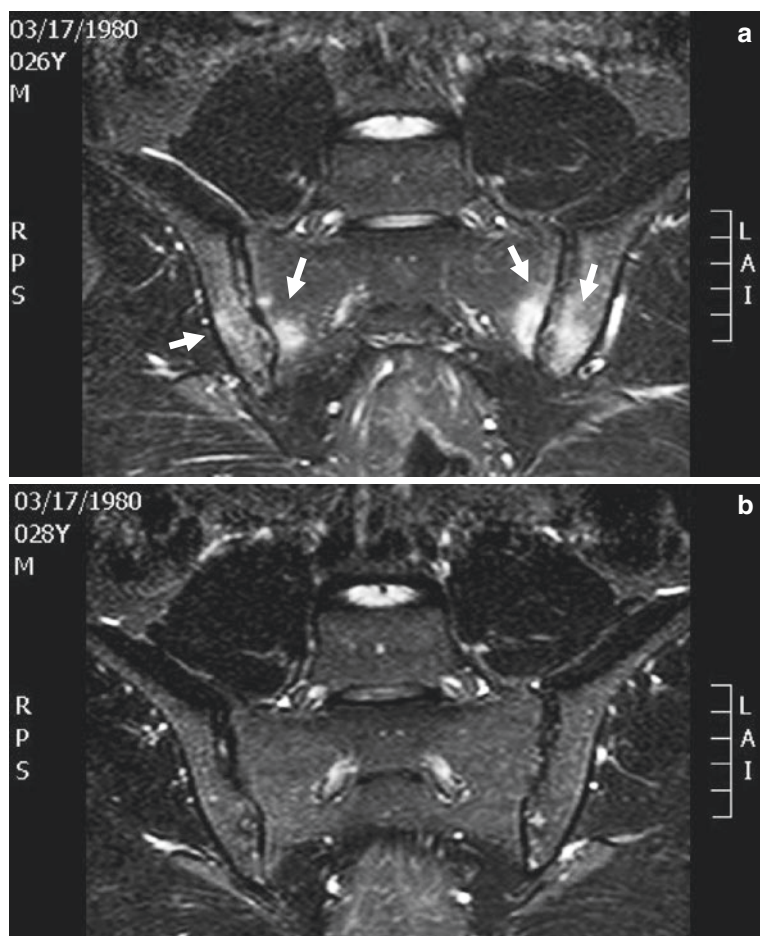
Magnetic resonance imaging of the sacroiliac joints in a patient after treatment with TNFi
